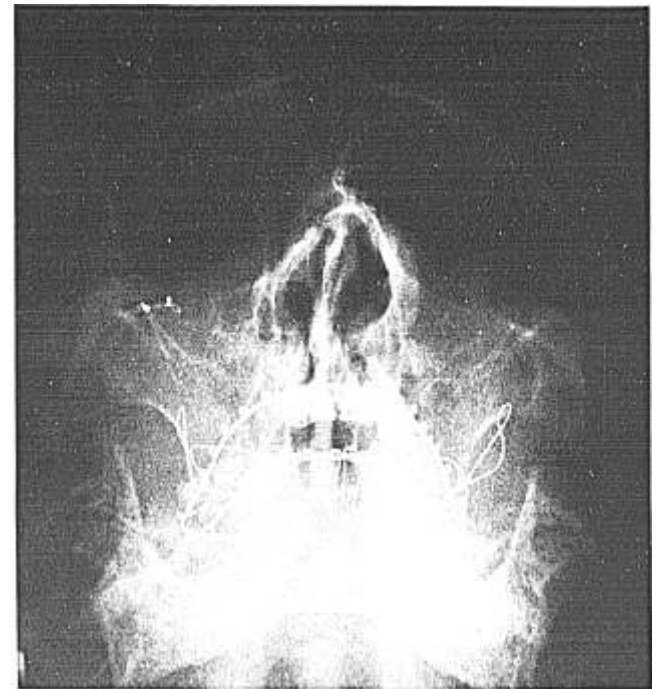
Postoperative roentgenogram, demonstrating: 1) arch bars *in situ*; 2) repair of the fractured sites.
